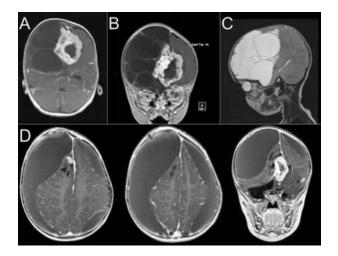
Preoperative MRI images showing a frontal cystic enhancing lesion with associated subdural fluid collections. The right one is bigger and posterior–superior compared with the cysts. The left one, smaller, is present only towards the vertex. A = axial T1-weighted scan with gadolinium; B = coronal T1-weighted scan with gadolinium; C = sagittal T2-weighted scan; D = axial and coronal T1-weighted scans with gadolinium.
